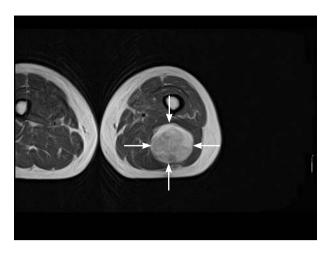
Magnetic resonance image of the left thigh shows giant sciatic nerve Schwannoma
